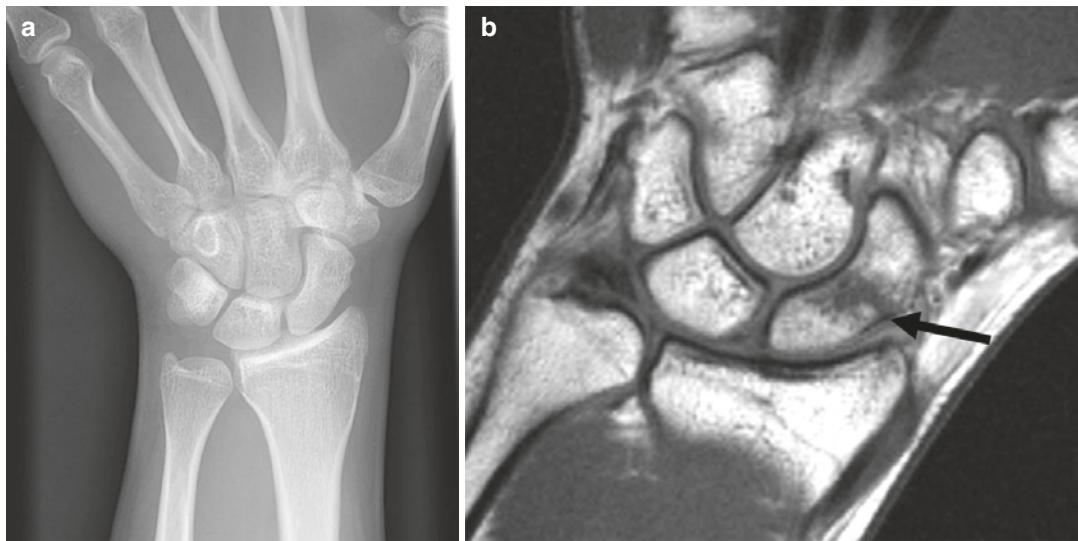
Twenty-two-year-old man with fall on outstretched hand. Scaphoid/ulnar deviation radiograph (a) is negative for fracture. Coronal T1-weighted MR image demonstrates a non-displaced fracture of the scaphoid waist (b)
